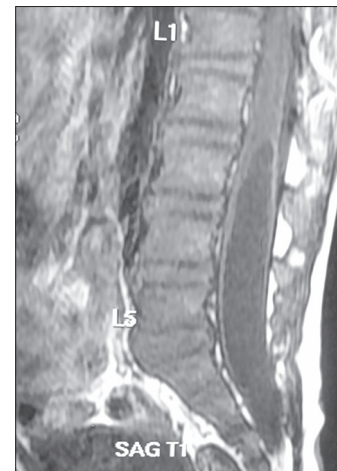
T1-weighted MRI showing hypodense intradural cystic lesion extending from L2 to S2
